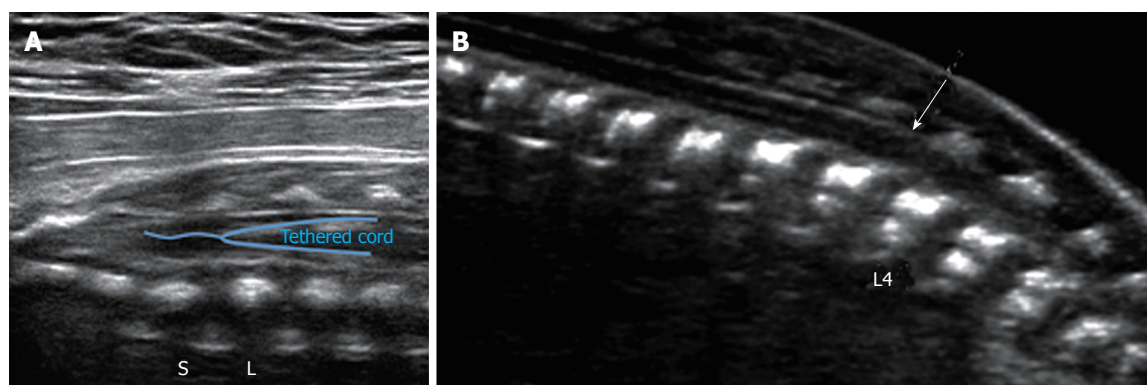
Spinal tether ultrasound. Grayscale ultrasound image (A) of the lumbosacral spine in a 29 wk fetus demonstrates a low-lying conus medullaris, extending below the lumbosacral junction (L/S). No evidence of associated fatty filum terminale was seen in this case; B: Grayscale ultrasound image of the lumbosacral spine in a 21 wk fetus demonstrates a low-lying conus medullaris (arrow), extending below the inferior endplate of L3. No evidence of associated fatty filum terminale was seen in this case.
